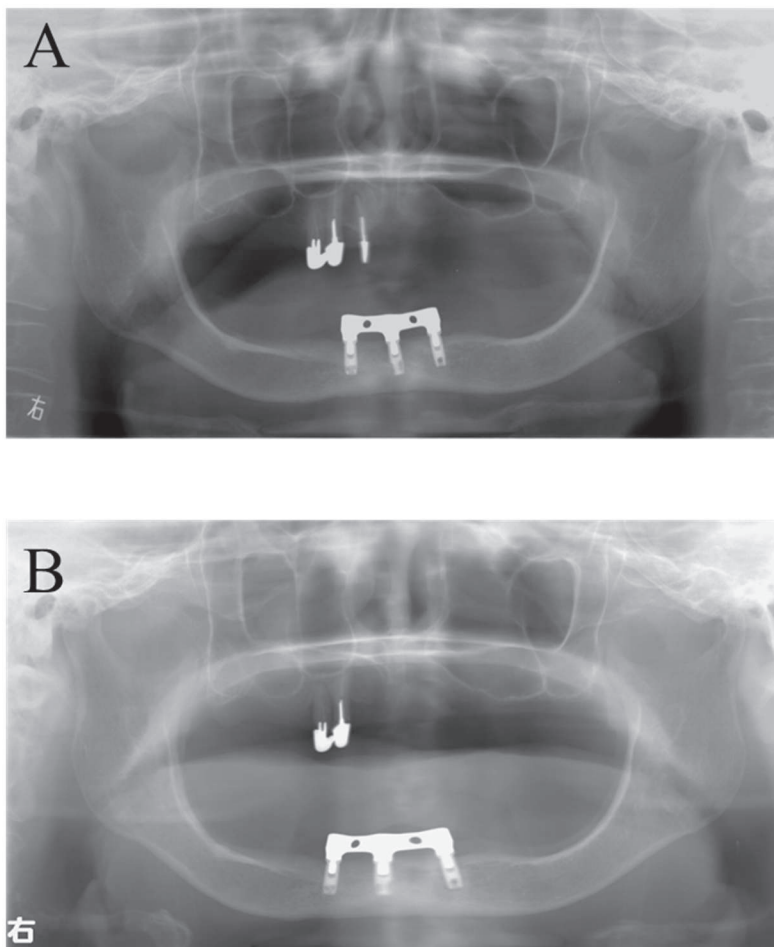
Panoramic X-ray: A. after 10 years of wearing dentures, B. after 17 years of wearing dentures
